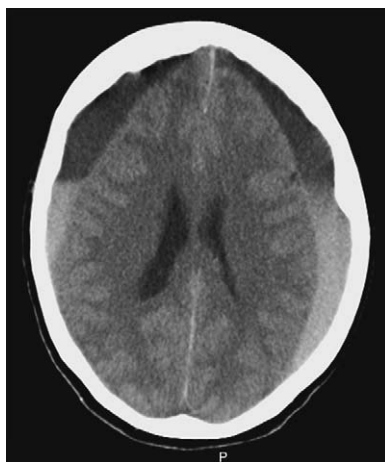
The computed tomographic characteristics of subdural hematomas (SDH) change over time. Acute subdural blood usually appears hyperdense to brain parenchyma. After approximately 1 week, the hematoma becomes isodense. By 3 weeks, most SDHs appear hypodense to adjacent parenchyma [102]. Mixed density blood collections, as seen in this noncontrast CT, usually represent acute on chronic bleeding. This elderly woman was found down and had a recent history notable for 3 weeks of gait instability and confusion.
